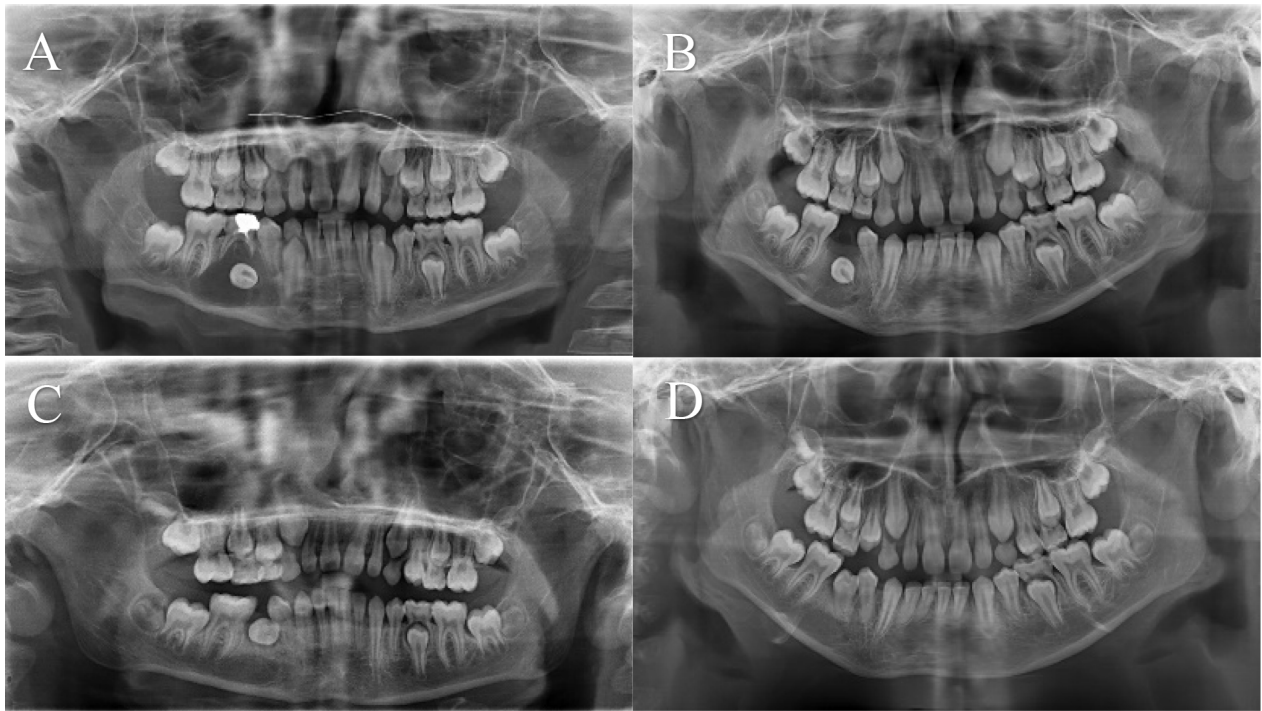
Case 1: panoramic radiographic findings during treatment. (A) Pre-operative. (B) Post-operative 3-month follow-up. (C) Post-operative 6-month follow-up. (D) Post-operative 12-month follow-up.
